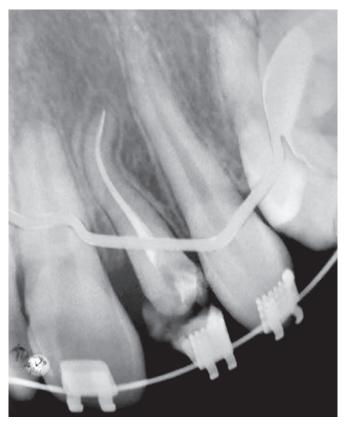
Final periapical radiograph.
